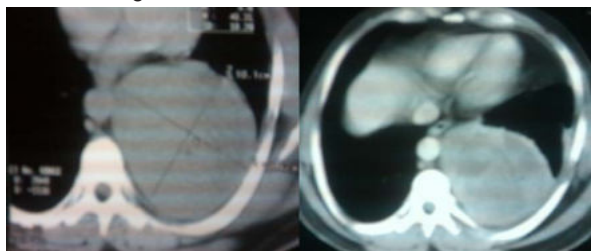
Schwannoma: Axial Non-contrast CT scan shows an well defined, hypodense lesion in posterior mediastinum. Which on post-contrast study shows heterogeneous contrast enhancement.
